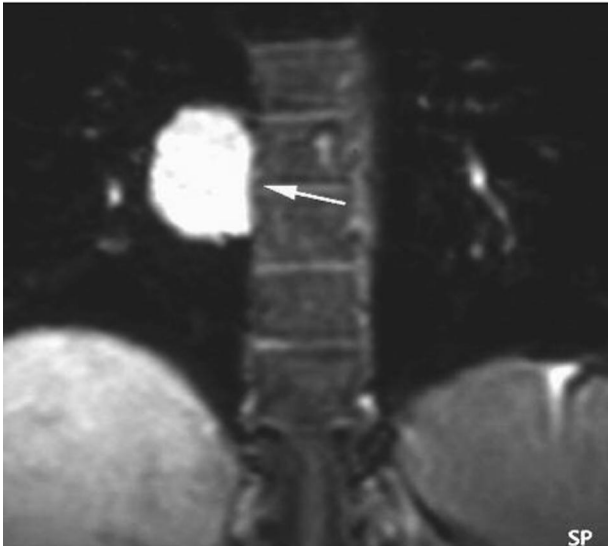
A 37-year-old woman with a bronchogenic cyst. A coronal T1-weighted magnetic resonance image shows a cyst with high-signal intensity contents (arrow).
